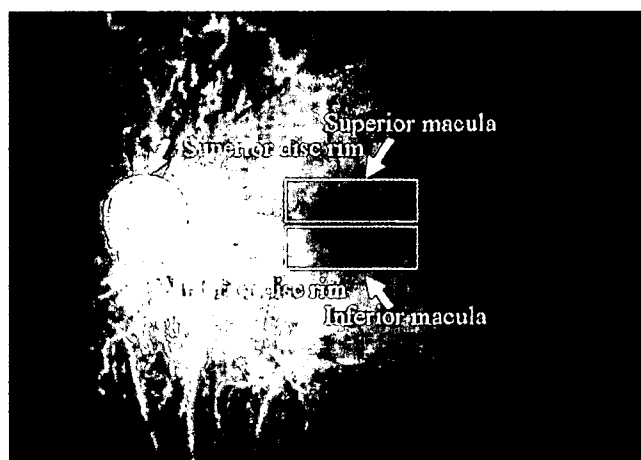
Measurement regions at the neuroretinal disk rim and macular area. Each area was divided into superior and inferior areas. Each measurement was performed three or more times and analyzed by scanning laser Doppler flowmetry.
